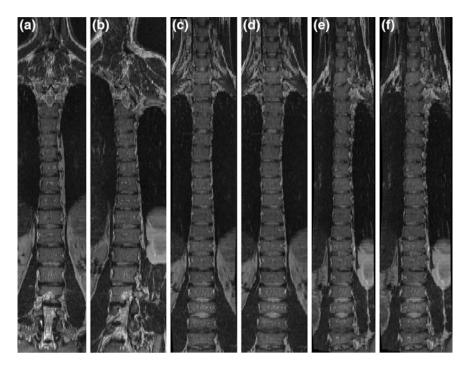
A coronal cross-section of a 3D MR image of a normal spine, obtained by a orthogonal MPR, b oblique MPR, c orthogonal CPR (with anatomical deformations), d orthogonal CPR (without anatomical deformations), e oblique CPR (with anatomical deformations) and f oblique CPR (without anatomical deformations)
